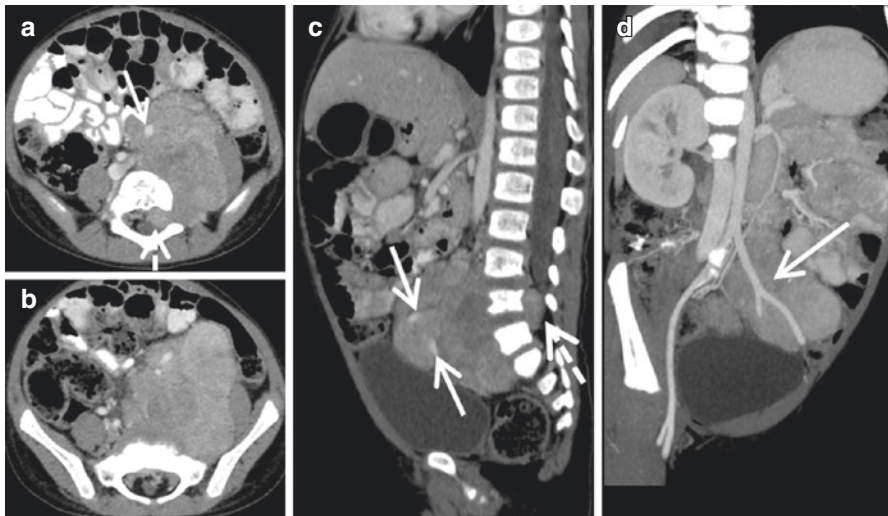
A 4-year-old boy with localized lumbar ganglioneuroblastoma (numeric chromosome alterations, INSS stage 3, INRGSS L2). Contrast-enhanced transverse CT scan (a, b), sagittal (c) and MIP coronal (d) views. The tumour demonstrates intense and heterogeneous enhancement. The tumour arises from the left paravertebral lumbar sympathetic chain. It encases left primitive, internal and external iliac arteries (arrows), infiltrates the L5-S1 left foramina and adjacent epidural space (dotted arrows)
